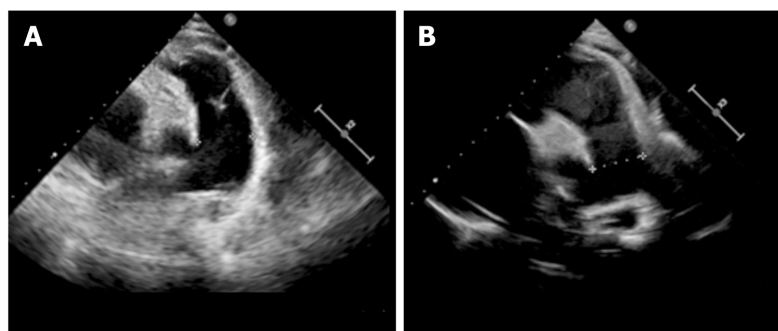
Echocardiography showed the changes in pulmonary artery diameter size before and after treatment. A: Before treatment, the size was 30 mm due to pulmonary hypertension; B: The size reduced to 25 with the decrease of pulmonary artery pressure.
